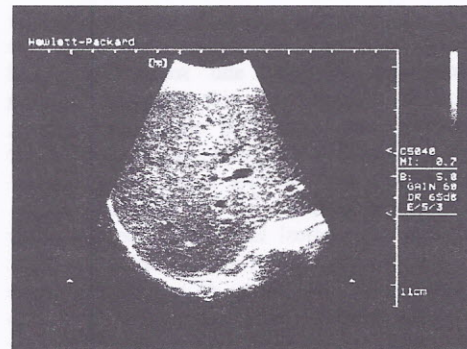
Sonographic image of liver and hepatic veins obtained with 5 MHz convex array.
